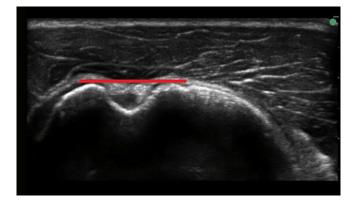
Ultrasound image of anatomic humeral retrotorsion measurement. The tuberosities were aligned while taking the measurement for anatomic humeral retrotorsion (line).
